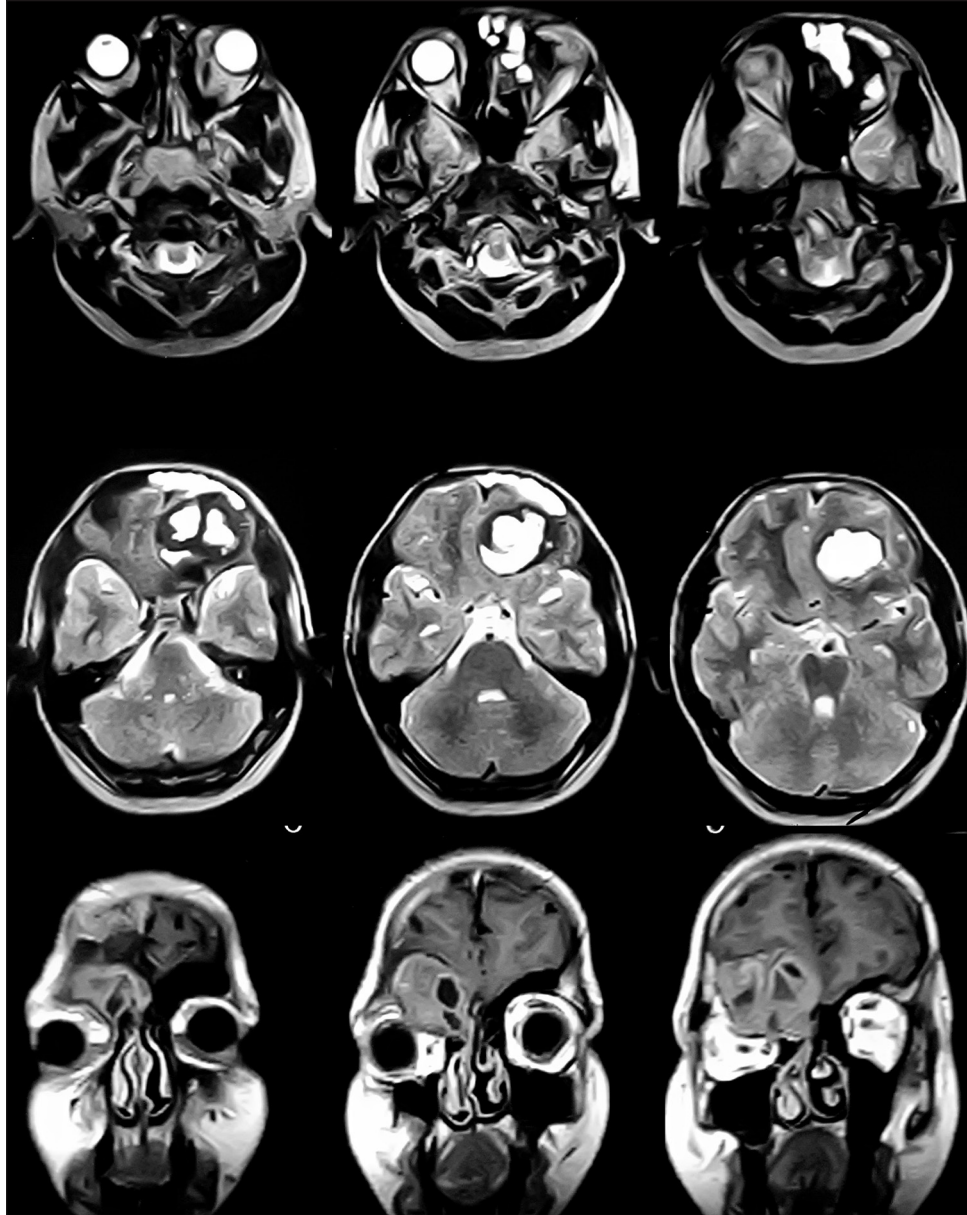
Pre-operative MRI Brain without contrast, T2 weighted axial images (top and middle row), demonstrating the extra axial nature of the lesion and mass effect on the frontal lobes with midline shift towards the right. T1 weighted post contrast coronal images (bottom row) demonstrates areas of heterogenous enhancement.
